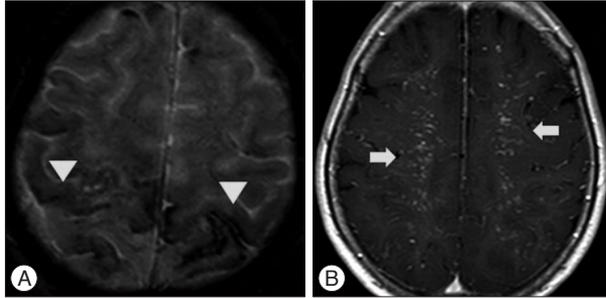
Brain magnetic resonance image showing multiple microbleeding (arrowheads) along the sulci of cerebral convexities on gradient echo image (A) and multiple vascular signals (arrows) on both centrum semiovale on gadolinium enhanced T1-weighted image (B).
